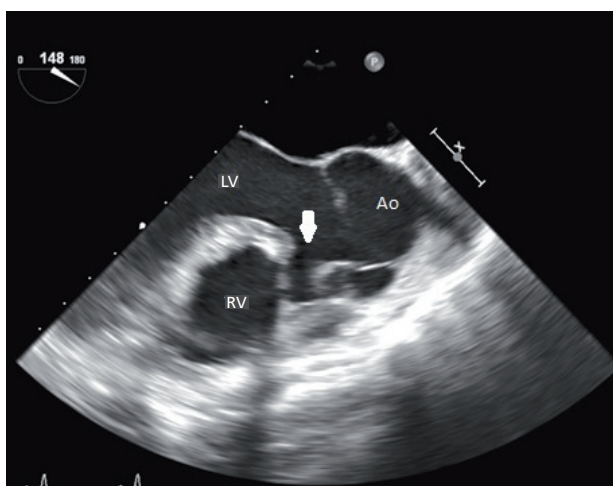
Transesophageal echocardiogram: subaortic ventricular septal defect (arrow).
